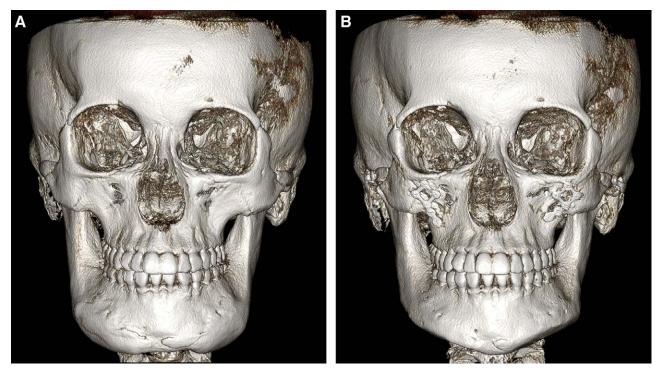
A, Preoperative computed tomography, showing the abnormal thickening of mandible. B, Postoperative computed tomography, showing that a substantial amount of the mandible was resected.
